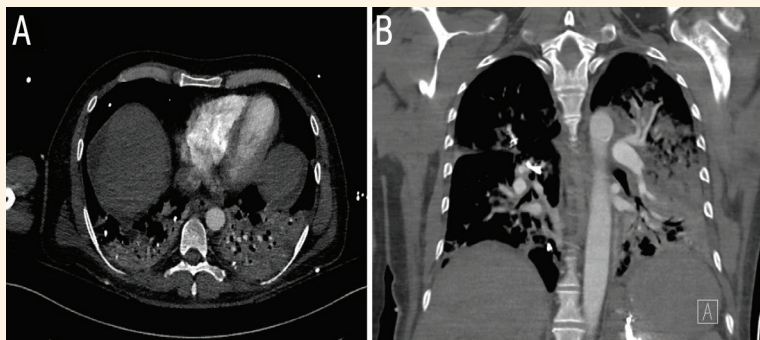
Axial computed tomography scan of a 65-year-old man following endoscopic sclerotherapy for the treatment of gastric varices demonstrating bilateral lower lobe consolidation and hyperdense linear structures within the *lumen* and branches of the pulmonary arteries.
